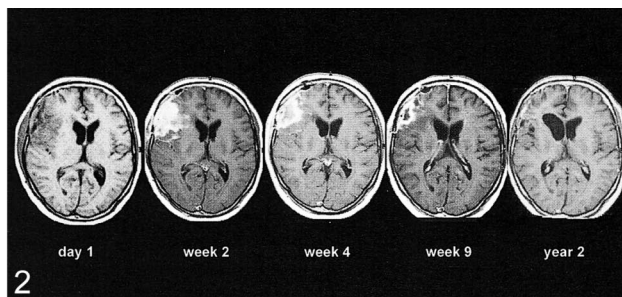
Flare enhancement. MR images obtained on day 1; weeks 2, 4, and 9; and year 2 after surgery. A strong flare develops after complete resection of all enhancing tissue within the frontal lobe. Later, there is shrinking and nearly complete disappearance of the process (enhanced T1-weighted axial MR images, patient 21).
